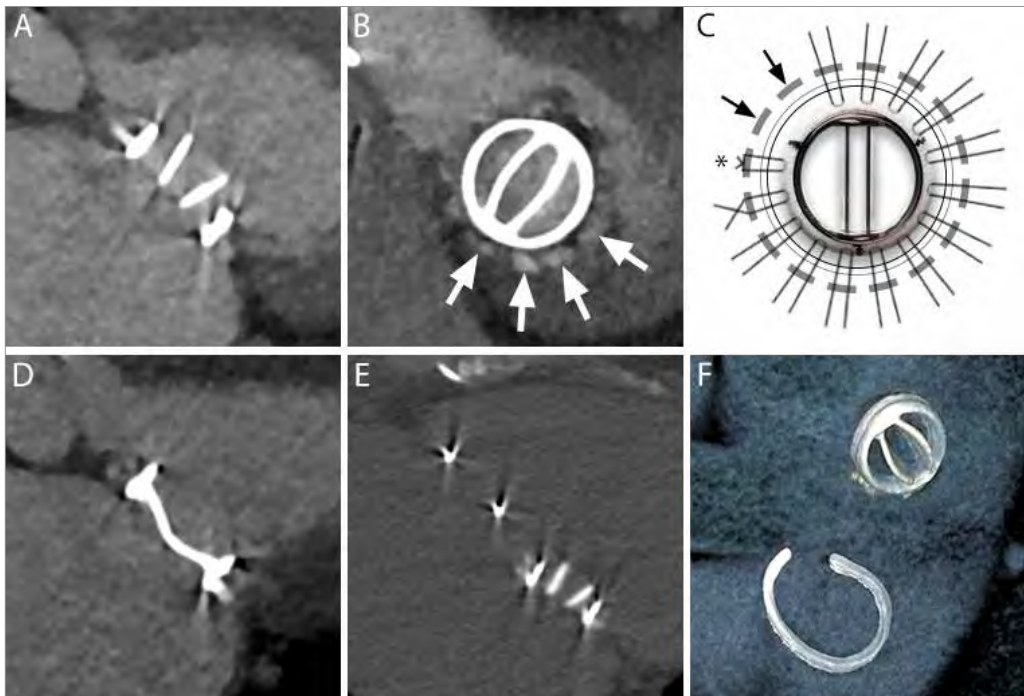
Comprehensive computed tomography angiography evaluation of a prosthetic mitral valve and tricuspid valve ring for suspicion of prosthetic heart valve endocarditis. Multiplanar reconstructions perpendicular (A) and parallel (B) to the valve plane in the open (A) and closed (D) phase, allowing for evaluation of valve function (compared with normal opening and closing angles provided by the manufacturer) and assessment of (sub)-valvular masses, such as vegetations, thrombus, or pannus. Often during implantation, surgical felt pledgets (arrows) may be used to strengthen the annulus (C) onto which the prosthetic heart valve is sutured (asterisk), which have a similar density as iodinated contrast on computed tomography angiography and may therefore mimic perivalvular extensions (B, arrows). An additional non-contrast enhanced scan (E) will allow differentiation between the two. On a three-dimensional volumetric rendering (F), a visual impression of valve function and possible 'rocking' of the valve (in case of dehiscence) can be gained.
